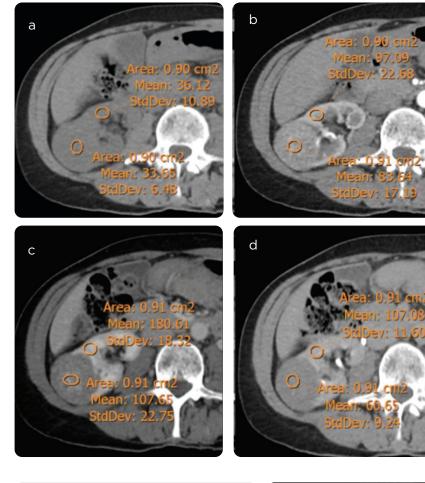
Multiphase CT in a 70-year-old woman. a) CT, phase without contrast medium, b) corticomedullary, c) nephrographic, and d) excretory. Heterogeneous formation in the upper pole of the left kidney. Density of the lesion and adjacent parenchyma  $\pm$  SD was calculated in each phase.
